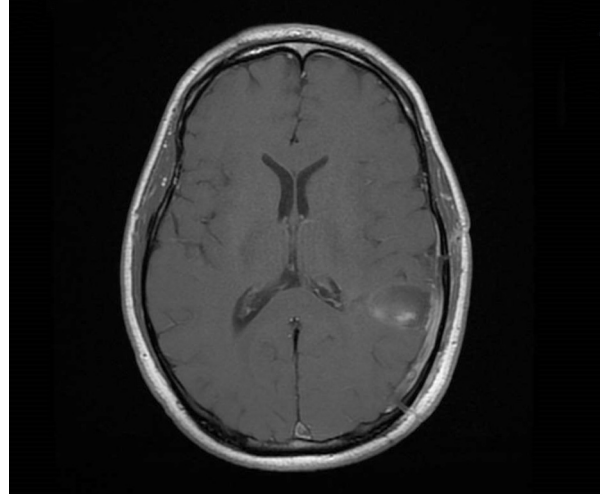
Postoperative control magnetic resonance imaging (3 months), axial T1 contrasted: no tumor remnants or appearance of new lesions are observed.
